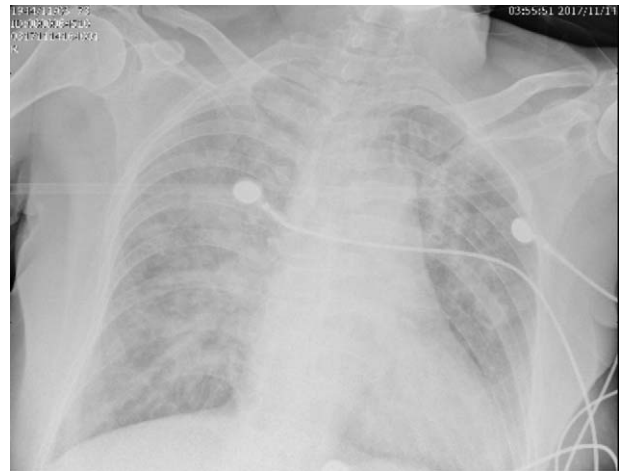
The pulmonary edema shown on chest radiography.
